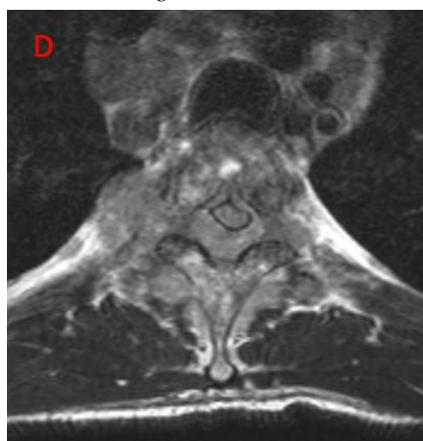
Axial MR images. (D) T1-weighted with gadolinium showing epidural lesion at T4 resulting in spinal cord compression. The lesion also extends into the foramen and paraspinal soft tissues.
